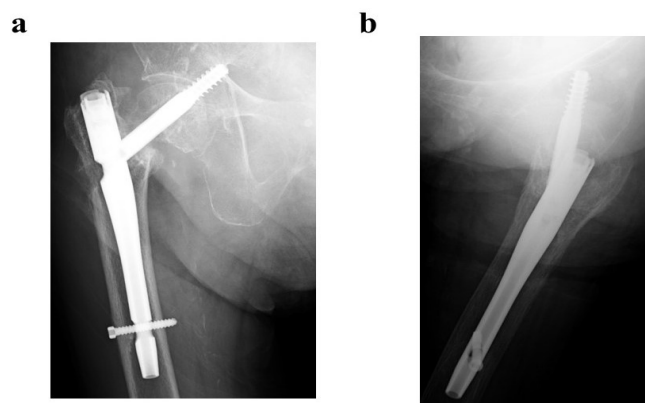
AP (a) and axial (b) radiographs of the right hip at the four months after the operation. The lag screw was almost completely free from the nail and into the pelvis.
